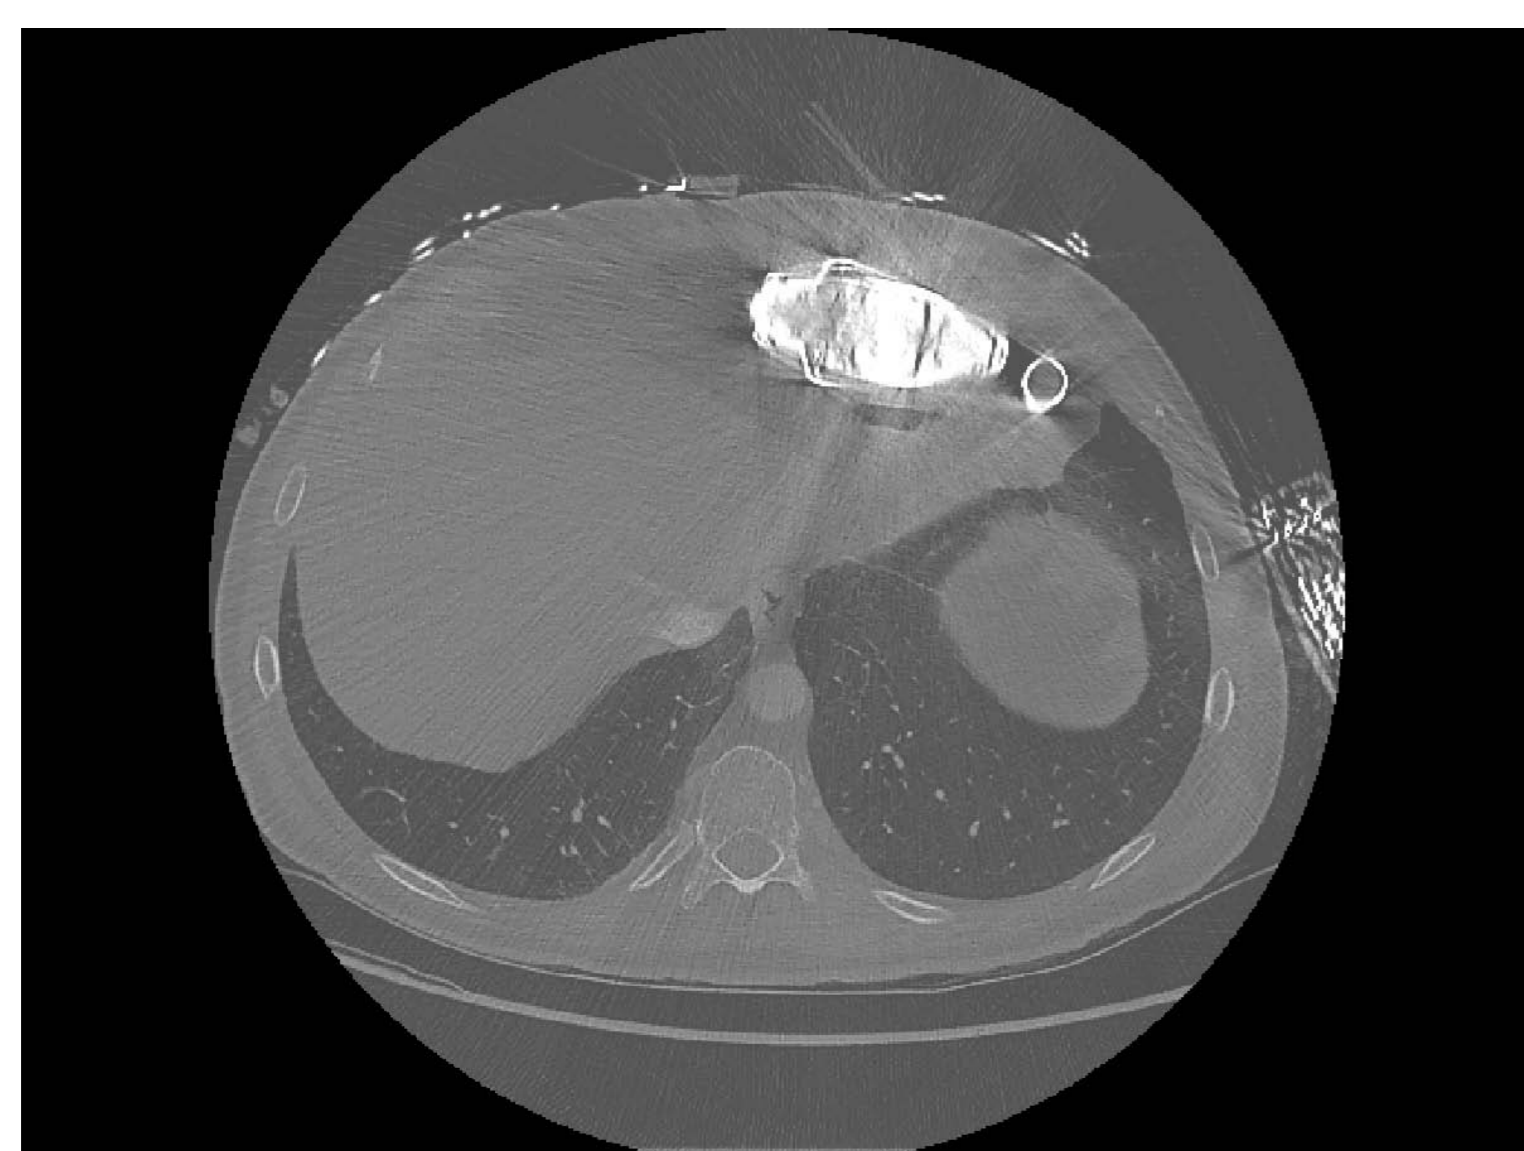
CT-scan of a patient with a continuous flow LVAD. Note the noise and artifacts induced by the presence of the device
